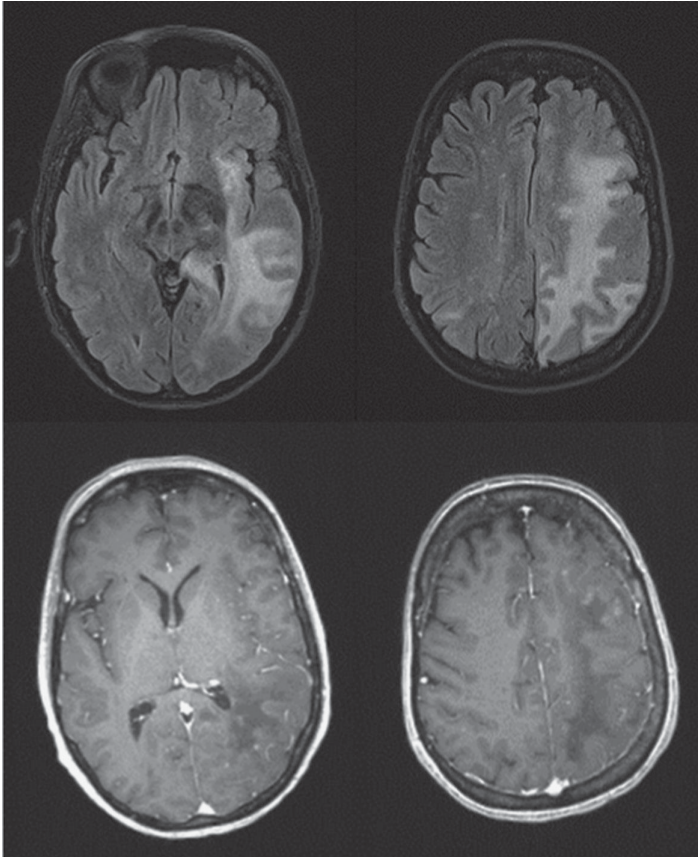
MRI 8 weeks after presentation (top row-FLAIR sequence, bottom row-T1 post-gadolinium sequence). While the FLAIR abnormalities are slightly more extensive than in Figure 2, the decrease in gadolinium contrast enhancement after corticosteroid therapy indicates resolving IRIS.
